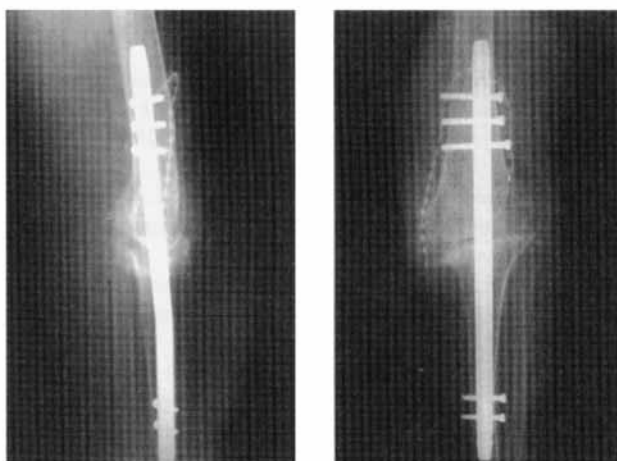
a.* Postoperative lateral xray. *b.* Postoperative AP xray.
